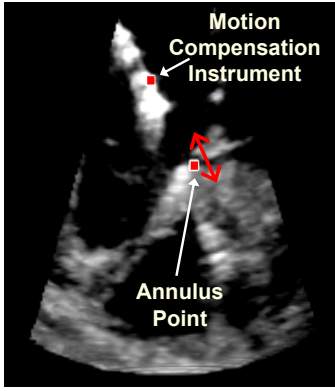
Slice through real-time 3D ultrasound volume showing tissue tracking. Squares denote the instrument with tip-mounted force sensor and the surgical target located on the mitral valve annulus.
